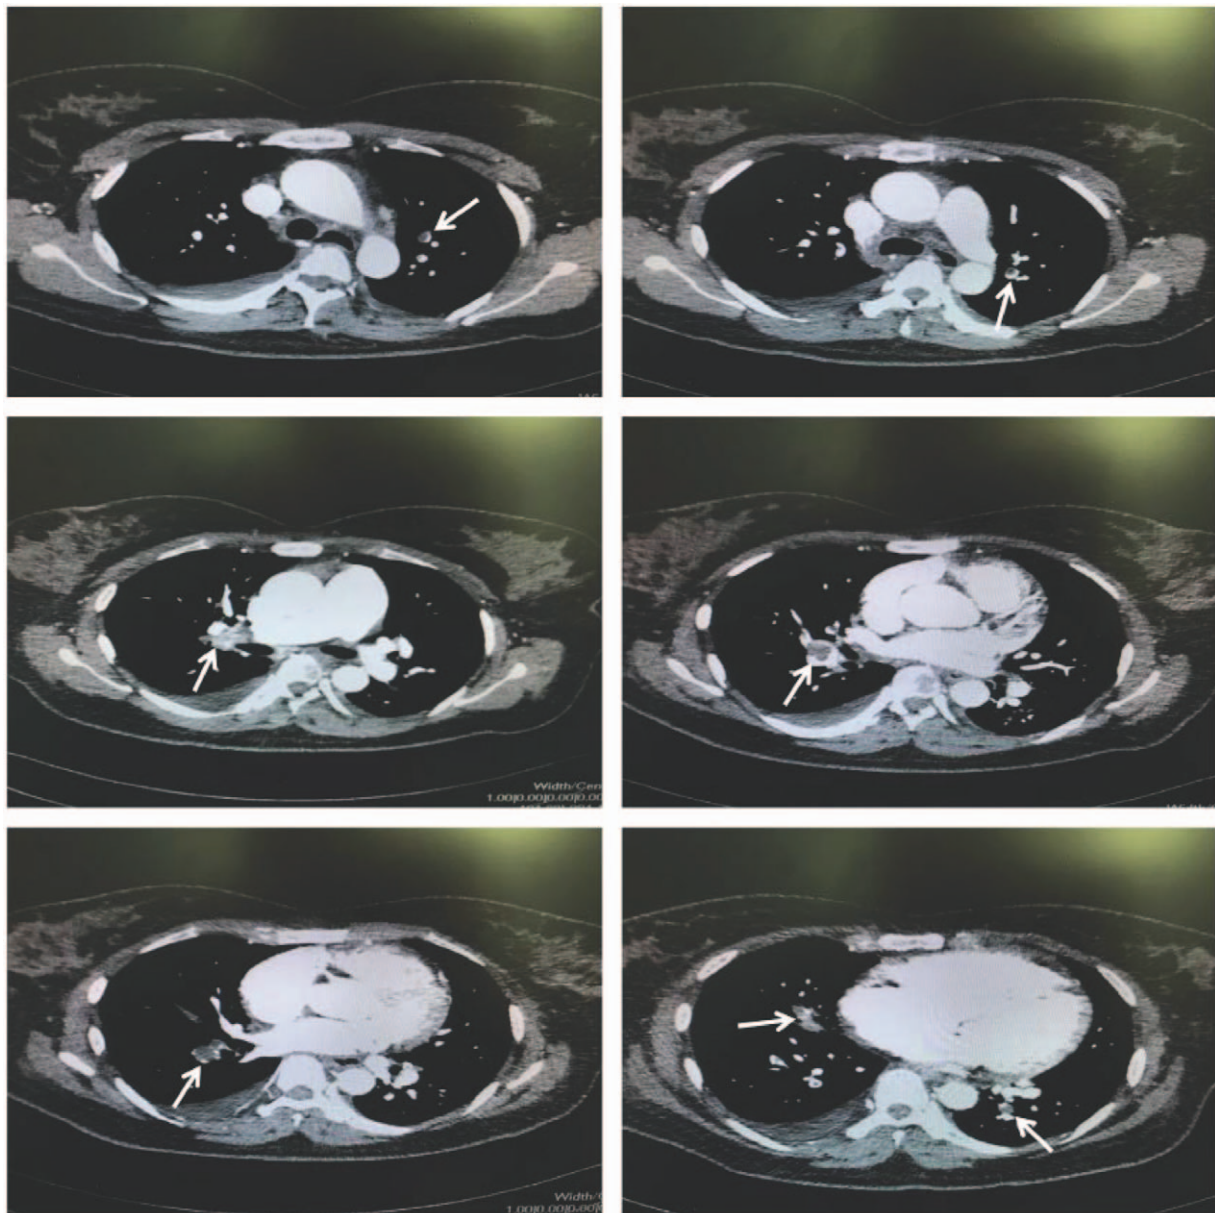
Computed tomography (CT) pulmonary angiography showing thrombus in the right pulmonary artery and branches of the left pulmonary arteries. CT= computed tomography.
